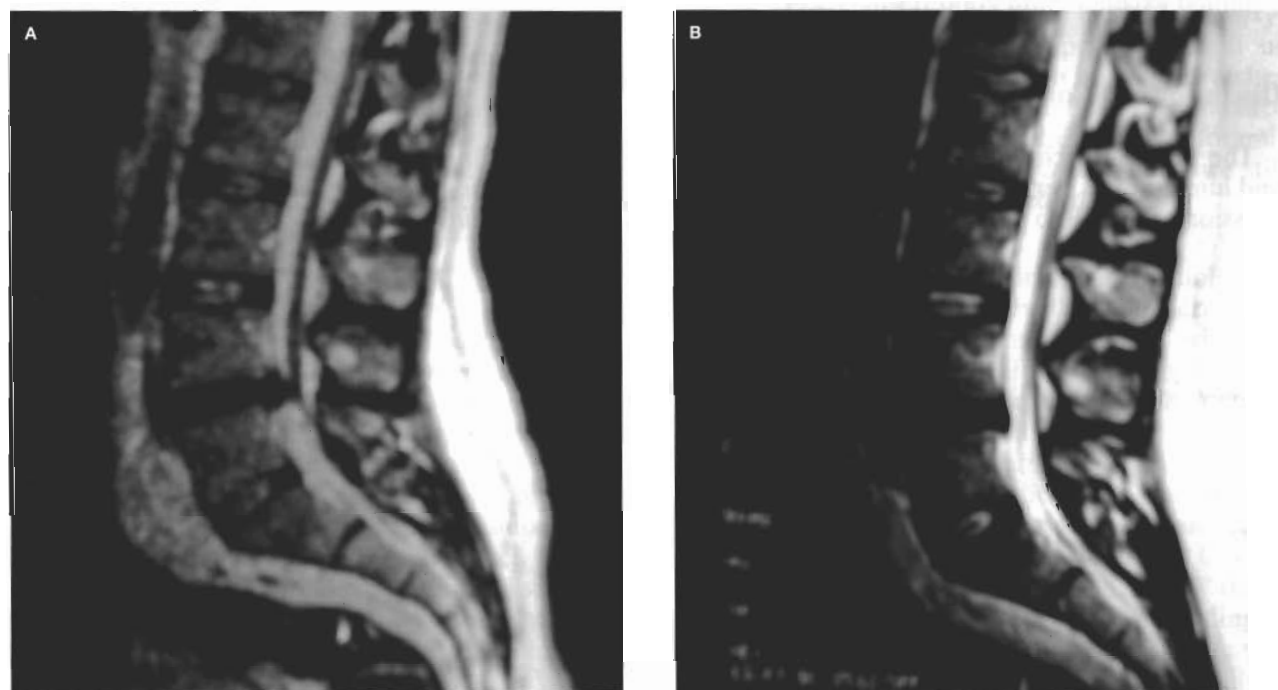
(A) Large herniated disc L4-L5. (B) Follow-up MRI four months after oxygen-ozone treatment showing complete disappearance of the disc herniation.
